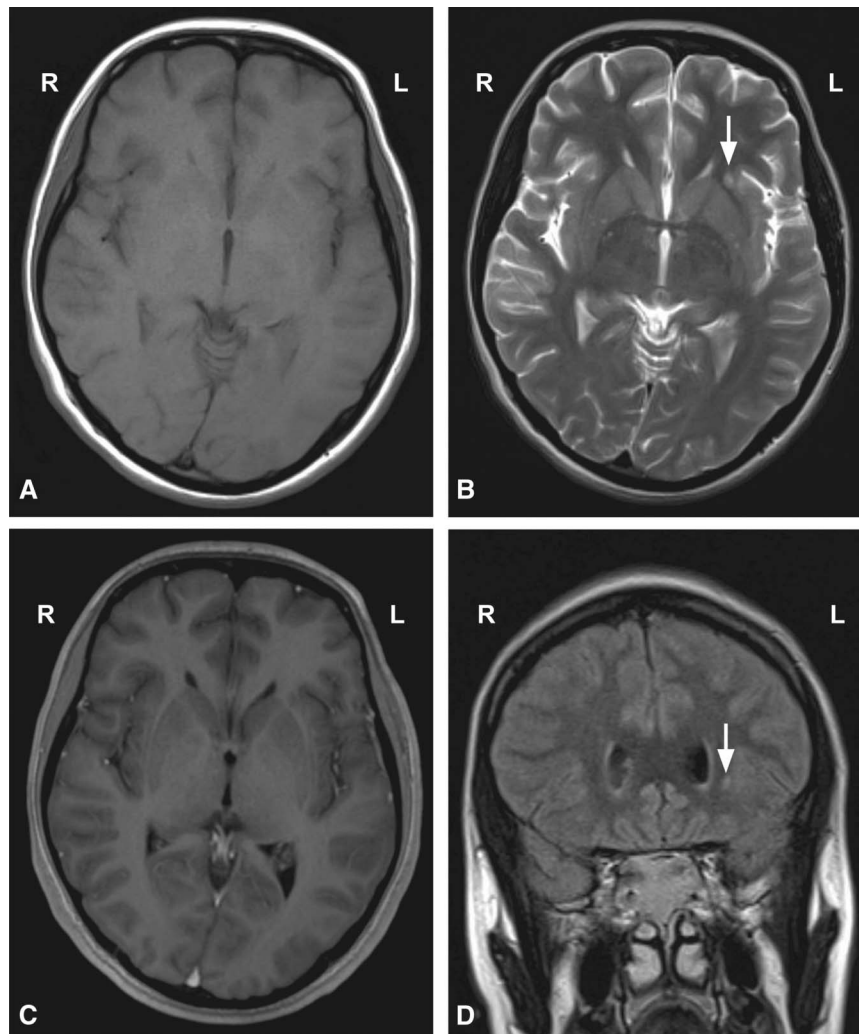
Brain magnetic resonance imaging includes noncontrast axial T1 (A), T2 (B), postcontrast T1 (C), and coronal fluid-attenuated inversion recovery (FLAIR) (D) images. An area of increased signal (arrows) is present on the T2 (B) and FLAIR (D) scans.
